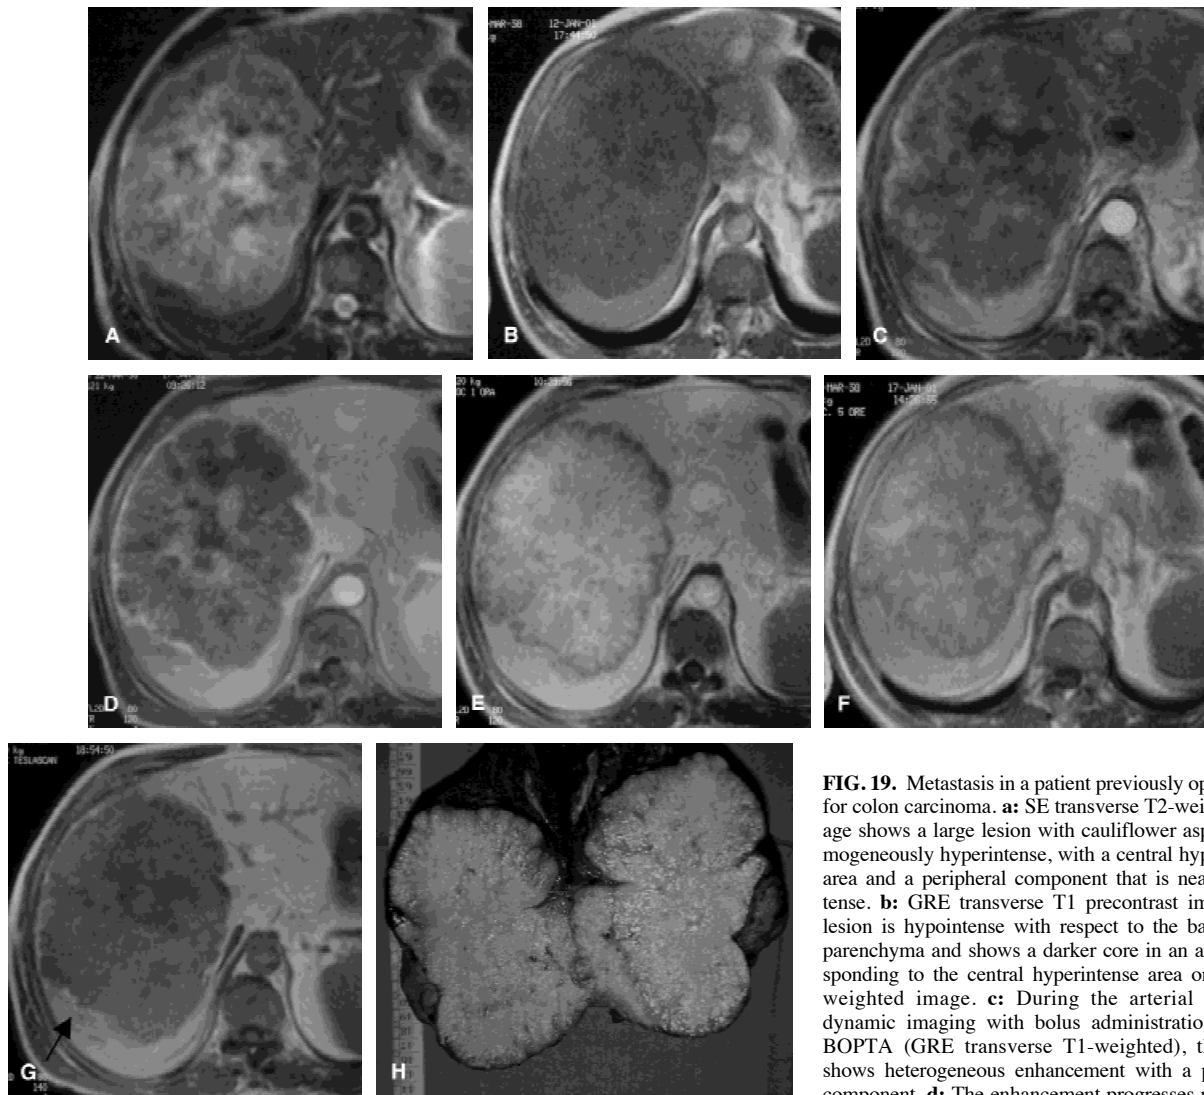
Metastasis in a patient previously operated on for colon carcinoma. a: SE transverse T2-weighted image shows a large lesion with cauliflower aspect inhomogeneously hyperintense, with a central hyperintense area and a peripheral component that is nearly isointense. b: GRE transverse T1 precontrast image. The lesion is hypointense with respect to the background parenchyma and shows a darker core in an area corresponding to the central hyperintense area on the T2-weighted image. c: During the arterial phase of dynamic imaging with bolus administration of Gd-BOPTA (GRE transverse T1-weighted), the lesion shows heterogeneous enhancement with a peripheral component. d: The enhancement progresses more centrally in the portal venous phase. e: In the hepatobiliary
